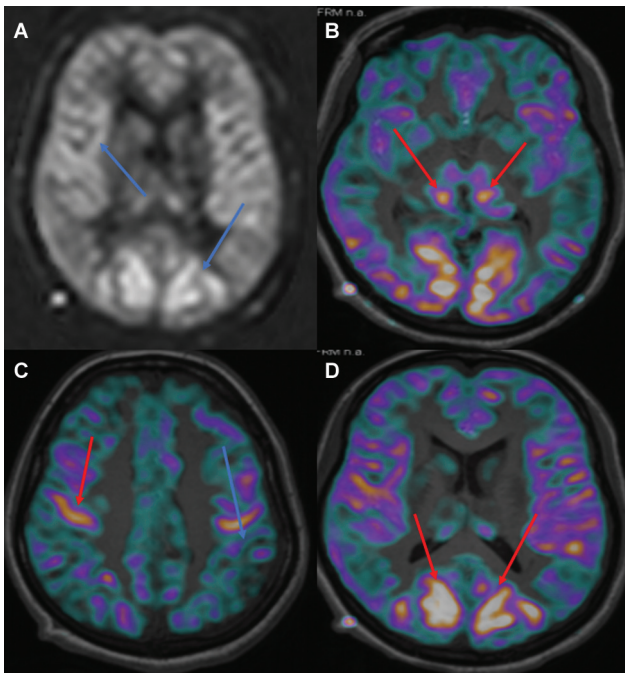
Perfusion weighted images using arterial spin labeling. (A) Grayscale arterial spin labeling (ASL) image shows bilateral symmetric cortical hyperperfusion (*blue arrows*). (B) Fused ASL T1-weighted (T1W) image shows symmetric hyperperfusion in bilateral thalami (*red arrows*). (C) Fused ASL-T1W image shows hyperperfusion in precentral gyrus (*red arrow*) with relatively reduced perfusion in postcentral gyrus (*blue arrow*). (D) Axial fused ASL-T1W image shows bilaterally symmetric hyperperfusion in bilateral occipital lobes (*red arrows*).
